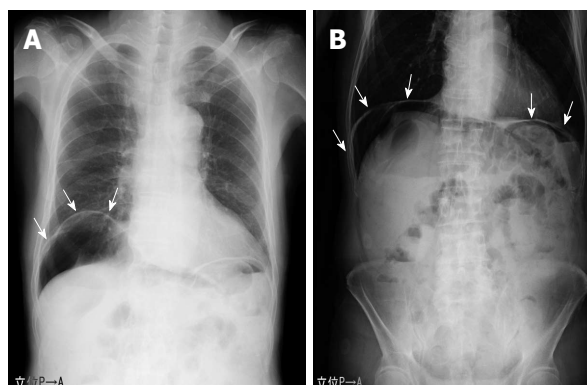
Plain radiograph demonstrating massive intraabdominal free gas bilaterally in the subdiaphragmatic spaces (white arrows). Grape-like clusters or honeycomb-shaped shadows, which are characteristic of pneumatosis cystoides intestinalis, were not observed.
